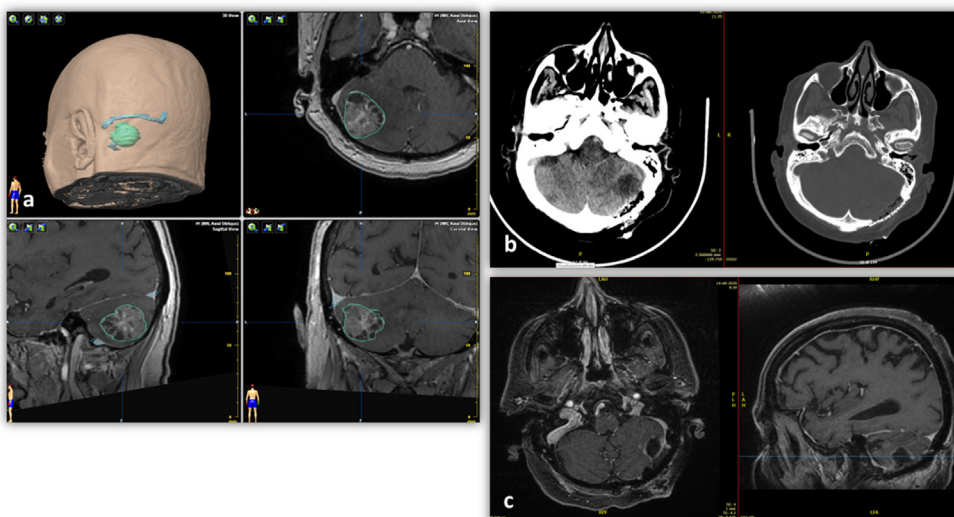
a: 3D reconstruction and axial, sagittal and coronal T1 weighted MR images with Gadolinium of a large hemispheric right cerebellar metastasis in an 80-year-old female affected by ovarian cancer (RPA Class III, GPA score 1). b: post-operative axial CT scan with contrast showing an apparent complete removal of the lesion. c: axial and sagittal T1 weighted MR images with Gadolinium after SRS treatment, 4 weeks after surgery demonstrating local disease control. The patient died 8 months after surgery due to progressive systemic disease.
